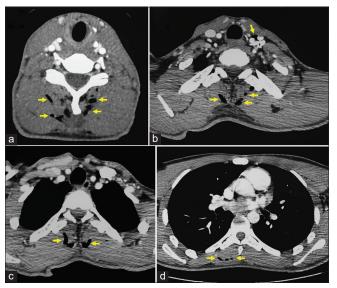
Axial cervical (a and b) and thoracic (c and d) computed tomography scan showing diffuse subcutaneous emphysema (arrows) in the posterior cervical and thoracic regions (a-d). Note additional gas in the left paralaryngeal area (b).
